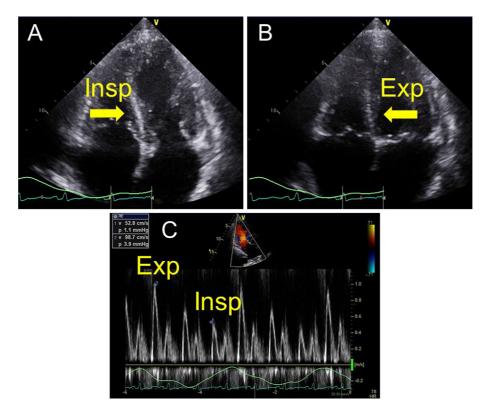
(A, B) Apical four-chamber echocardiographic view demonstrating the leftward ventricular septal shift during inspiration (yellow arrows). (C) Pulsed-wave Doppler recording at the level of the open mitral leaflet tips in the apical view showing an inspiratory decrease and expiratory increase in early mitral inflow velocity. Exp: expiration, Insp: inspiration
